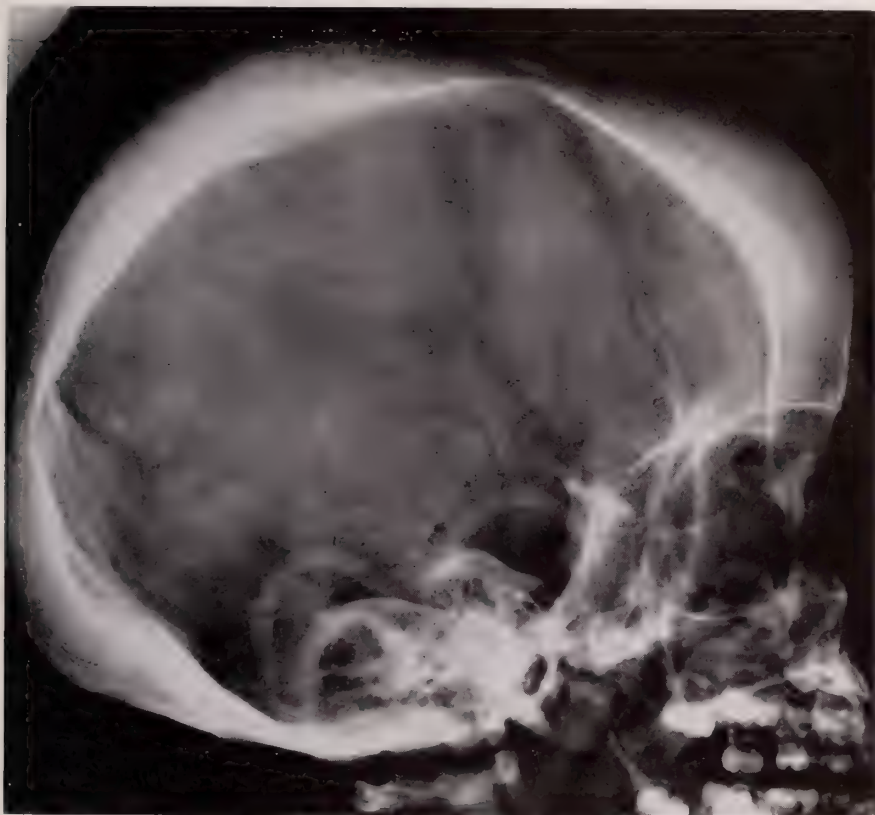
Iron Deficiency Anemia. The skull of a three year old Puerto Rican male shows widening of the diploic space. The parietal trabeculae show an early fine radial pattern. The outer table is atrophic in some areas and there is a generalized granular osteoporosis. The frontal, parietal and occipital bones are all affected but the occipital squamosa inferior to the internal occipital protuberance is uninvolved, probably because there is normally no marrow in this portion of the bone. This patient was born at term with multiple cutaneous hemangiomata and cerebral vascular anomalies. He was mentally retarded and would take no solid foods. His diet consisted almost solely of milk. There was a prompt response of the anemia to iron therapy. (Moseley, J. E.: *Am. J. Roentgenol. & Rad. Therapy*, 8: 649, 1961.)
